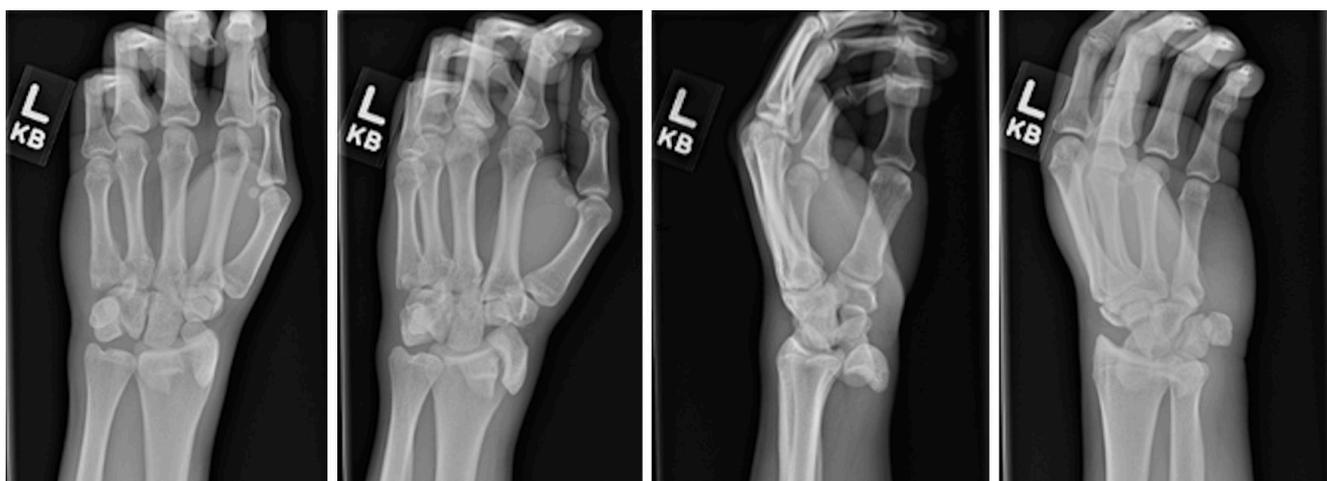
Demonstrates anterior-posterior (AP), lateral, and two oblique radiographic views of the left wrist demonstrating volar lunate and scaphoid dislocations.
